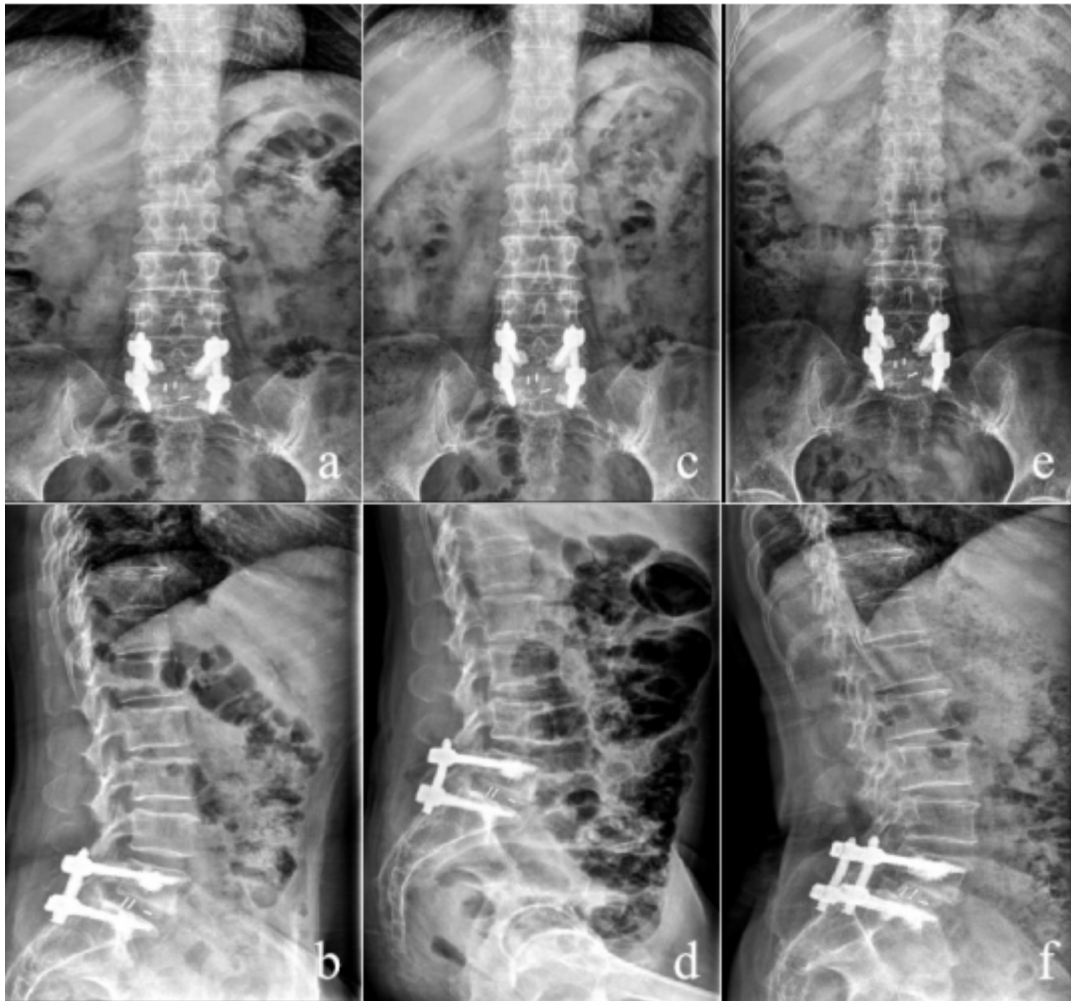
a-b, 3 months postoperatively, frontal and lateral radiographs of the lumbar spine showed good internal fixation, no loosening or retraction of the screw, and no collapse of the intervertebral fusion device. c-d, 6 months postoperatively, frontal and lateral radiographs of the lumbar spine showed bone trabeculae formation with good position of screw and intervertebral fusion. e-f, The final follow-up lumbar frontal and lateral radiographs showed continuous trabecular bone formation in the intervertebral space and Bridwell intervertebral bony fusion grade I.
